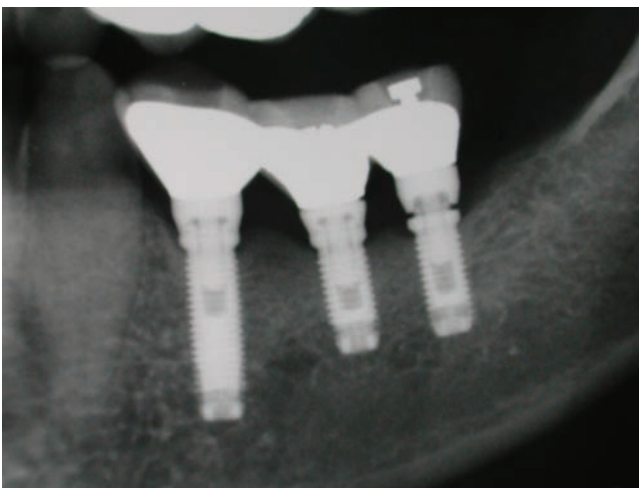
A radiograph of a posterior mandibular bridge on Branemark implants, showing failure to seat the distal abutment on the hex of the implant and an associated loose bridge screw.
